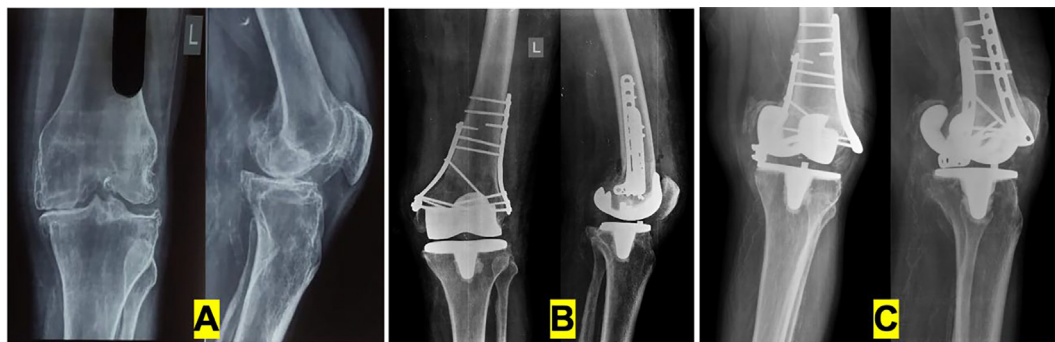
Type 4b fracture treated with both column plating non-union and implant failure. (a) Preoperative radiograph; (b) immediate postoperative radiograph; (c) 1-year follow up radiograph.
